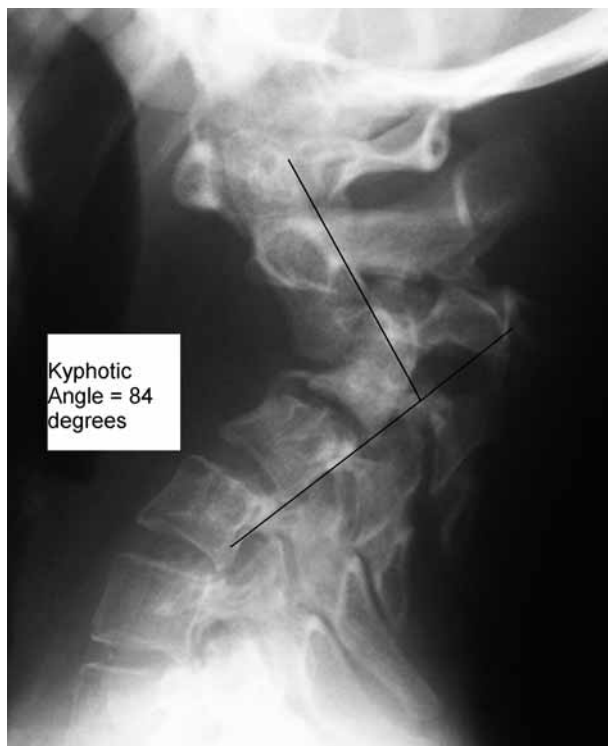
Plain lateral radiographs at the end of 3 months of halo vest immobilisation and antibiotic treatment showing an 84° kyphotic deformity and ossific bridge formation between C3/4.
